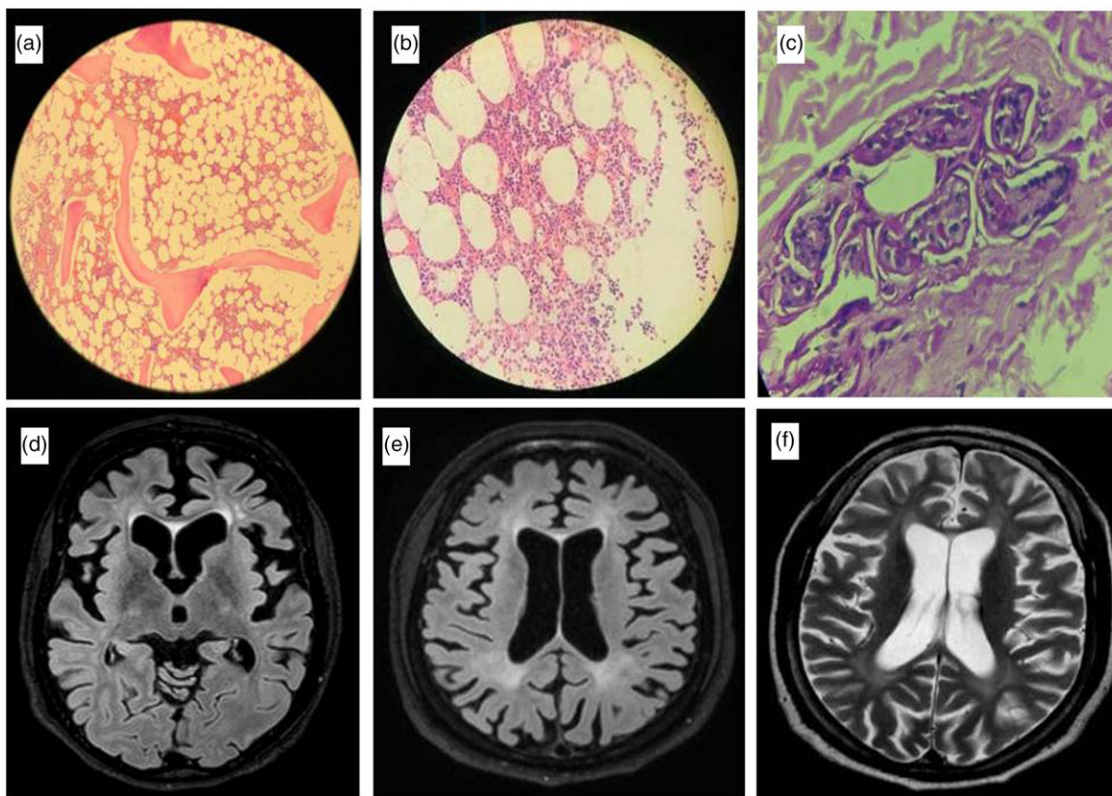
Bone marrow aspiration of case 2 showing foamy macrophages at 100× (a) and 400× (b) magnification. Skin biopsy at 400× magnification showing perivascular infiltration of histiocytes (c). MRI brain showing axial FLAIR image with predominant frontal atrophy in case 2 (d). Axial FLAIR (e) and T2 image (f) of case 3 showing periventricular hyperintensities along with diffuse atrophy.
